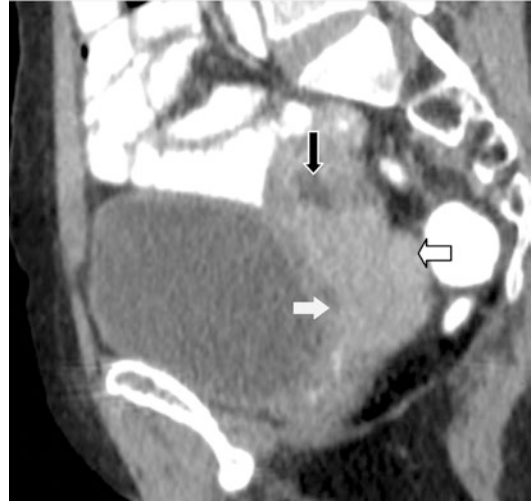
Sagittal CT scan of pelvis showing a soft tissue mass in the uterine cervix (thick horizontal white arrows), extending to the lower uterine body and upper vagina. There is mild endocavity collection (vertical black arrow)
